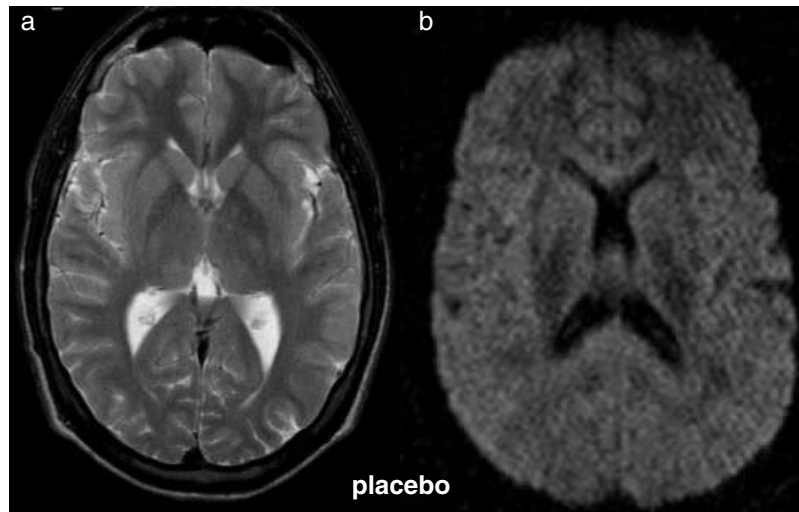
T2 weighted (a) and diffusion weighted (b) magnetic resonance imaging in subject no. 3 with very severe AMS (with placebo, AMS-score 10, see Table 1) without abnormal increase in signal intensity.
